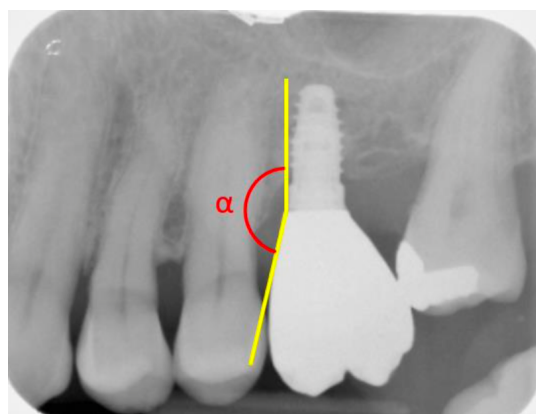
Prosthetic emergence angle (α), calculated on the periapical radiograph as the angle between the straight line passing through the abutment-implant junction and the straight-line tangent to the profile of the prosthetic crown.
